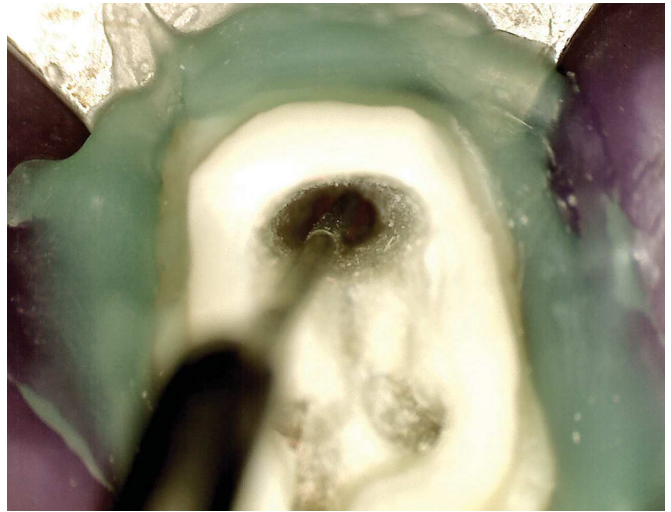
Dentin qualification carried out by QLF-D ultrasonic tip (Trinks, São paulo, SP, Brazil) with the objective of removing degraded dentin and excess gutta-percha from the palatal canal, thereby favoring adhesion.
